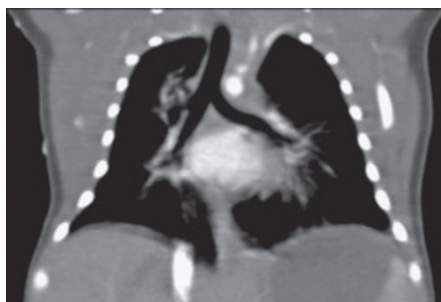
Chest CT of an infant showing proximal take-off of the right upper lobe bronchus.
